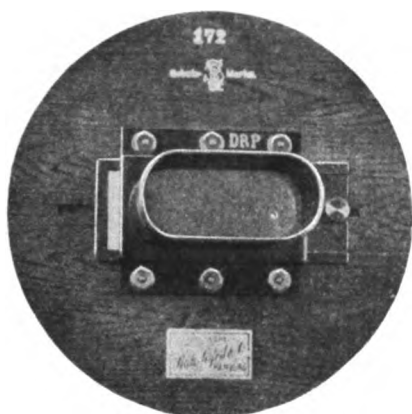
Walter skiameter, or fluorometer, for indicating the penetration of the radiation of an x-ray tube.
